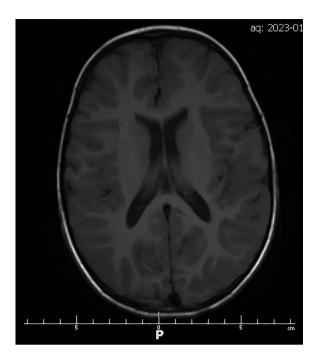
Normal brain image (magnetic resonance imaging of the central nervous system in axial T1-weighted image) Rycina 2. Prawidłowy obraz mózgowia (rezonans magnetyczny
